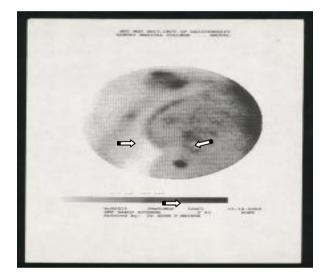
99mTc-MDP bone scintigraphy showing increased radio-tracer in the sites of bone metastases in right humerus, right ribs and primary of breast cancer patient (Arrows).
